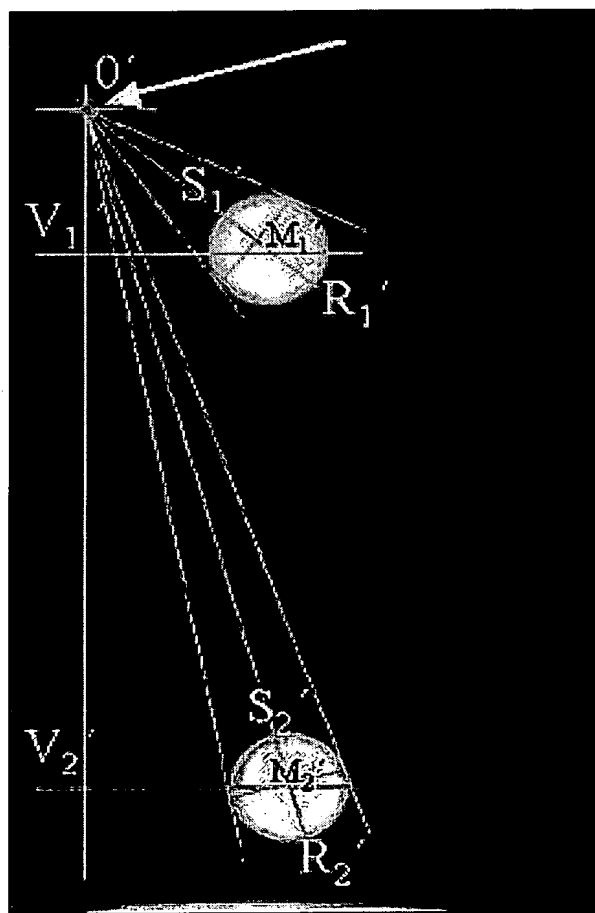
Geometrical construction on a radiographic image obtained with the experimental set-up, required to extract all relevant information on distortion for calculation of actual angulation. For better understanding landmark points as introduced in Figure 2 are included in the image. The arrow is indicating the circular image of marking sphere, with its center representing the point of incidence of central X-ray (point zero: O' (0; 0; 0))
